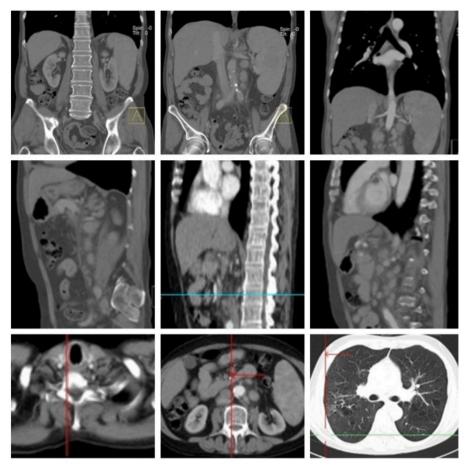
CT showed a gradual recovery as the tracheal node shrank into 1 cm, the right and left navel nodes measurements reached (14mm, 9 mm respectively). A significant bilateral reticular fibrosis was recognized with the appearance of honeycomb shape. Moreover, the largest aortic lymph node measured 3 cm.
